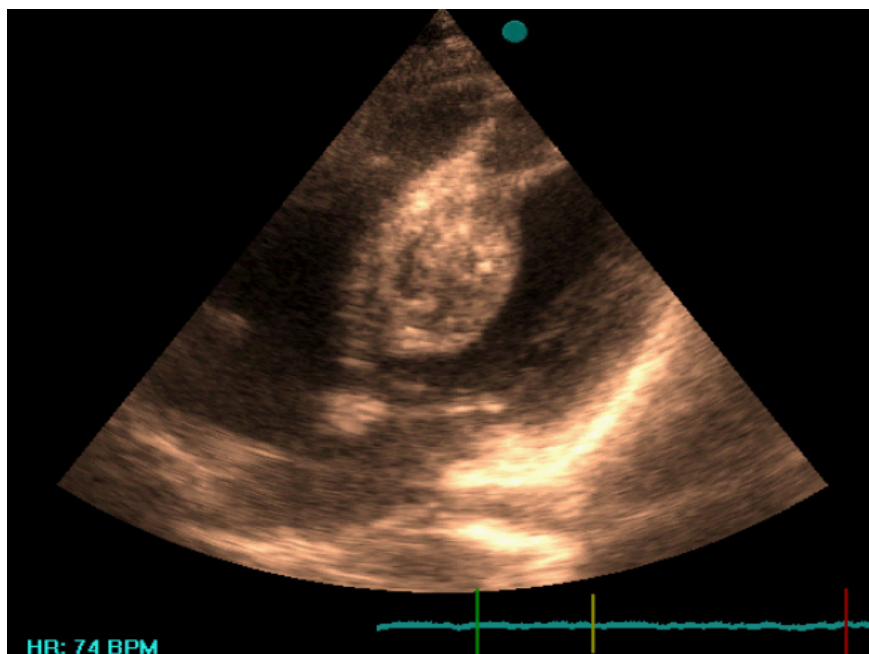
Transthoracic echocardiography in apical four chamber view shows hydatid cyst in the interventricular septum that contained some small daughter cysts
